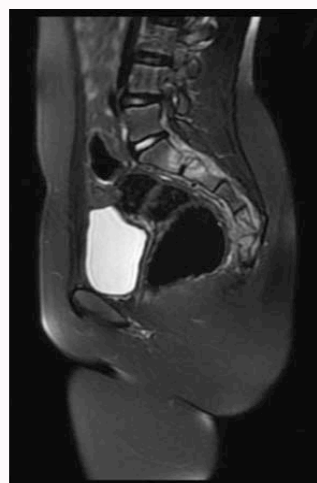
MRI sagittal T2 Fat Sat view of the sacrum, showing 2 lesions: One including the 1st and 2nd sacral element, the other one on the 4th and 5th.
